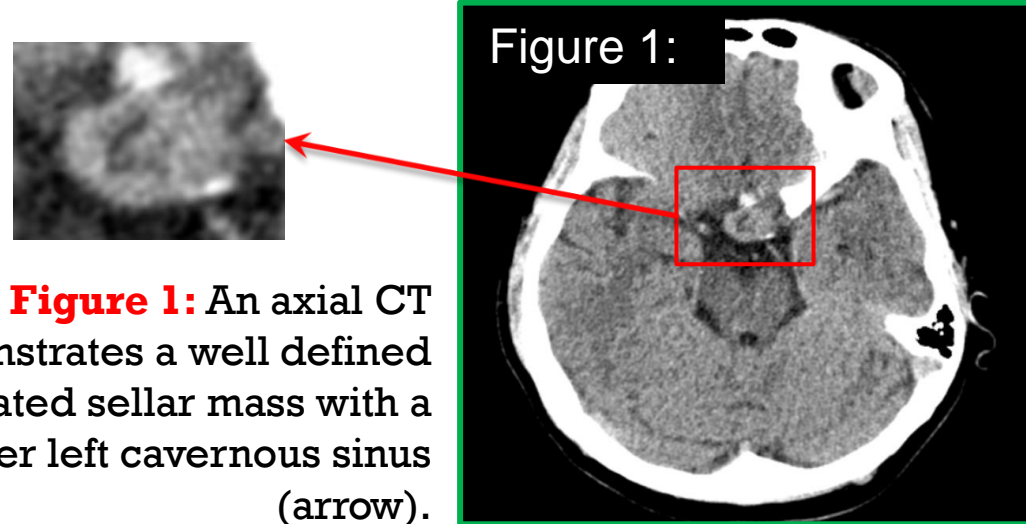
An axial CT demonstrates a well defined lobulated sellar mass with a fullness over left cavernous sinus (arrow).
